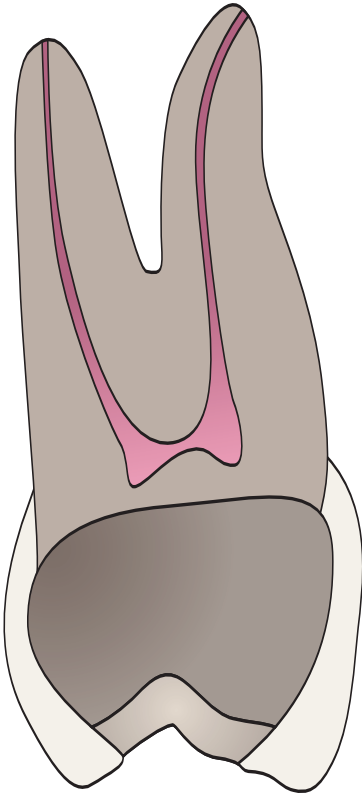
Operative errors—maxillary premolars. Overextended preparation from a fruitless search for a receded pulp. The enamel walls have been completely undermined and the tooth hopelessly weakened. Gouging relates to a failure to refer to the radiograph, that clearly shows the depth of pulp recession.
